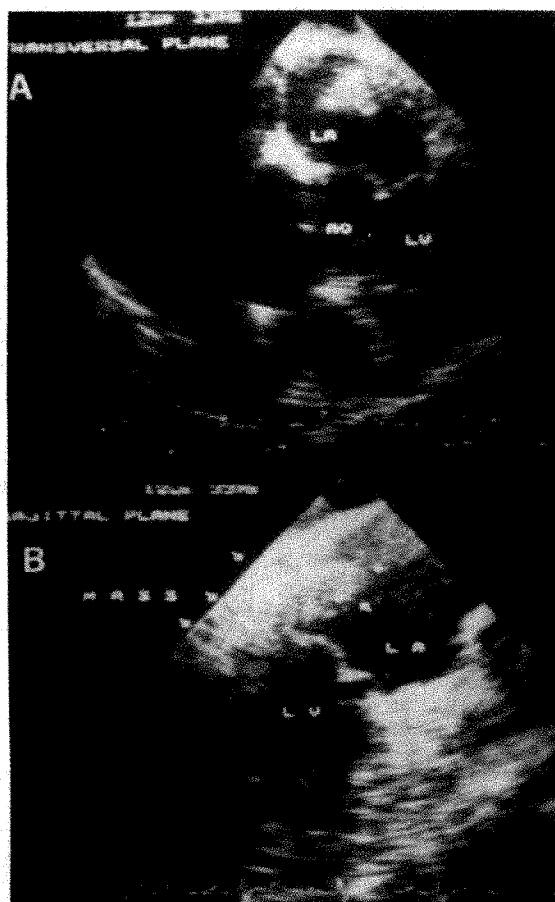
This 72-year-old man, affected by non-Hodgkin's lymphoma, was prospectively evaluated by echocardiography in order to assess the relation between the mediastinal mass and the cardiovascular structures. Both computed tomography and transthoracic echocardiography showed a posterior mass in close contact with the left atrium (LA). Transesophageal echocardiography showed a mobile mass within the left atrium, but in the transverse planes the relationships with the paracardiac mass were not clear (A). Using the sagittal plane, the infiltration of the posterior atrial wall and the continuity between paracardiac and intracardiac mass were demonstrated (B). AO = aorta; LV = left ventricle.
